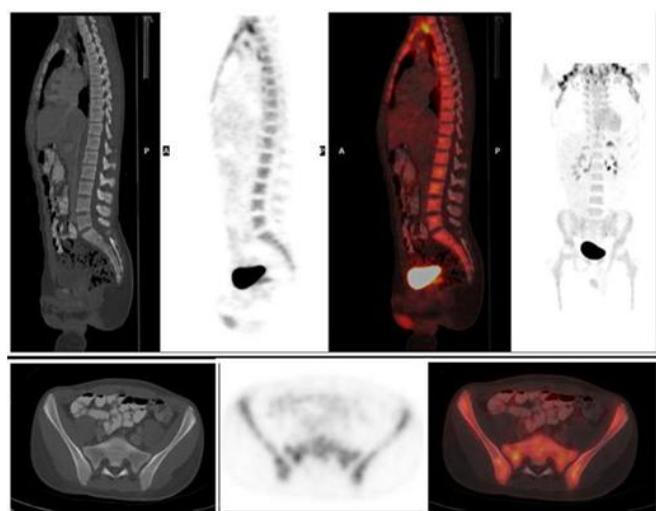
Sagittal sections of CT component, PET component and combined image. Coronal PET section. Axial sections of the pelvis of the CT component, PET component and combined image. The patient received a bone marrow transplant, with uptake in the entire axial and peripheral skeleton due to granulocyte colony-stimulating factor.
